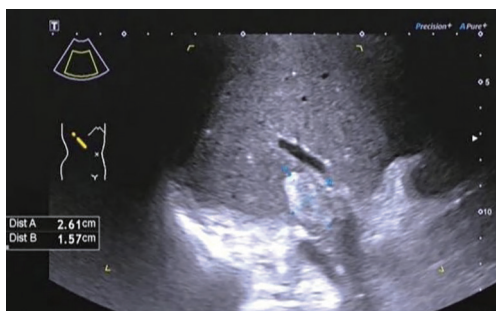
Abdominal ultrasound revealed a perivascular hyperechoic nodule in the 7th segment of the liver.
